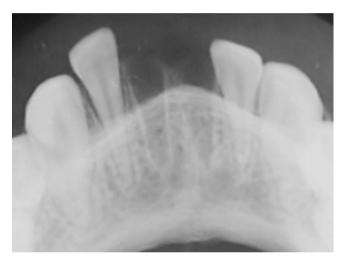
Lower occlusal radiograph shows a complete avulsion of the mandibular right and left central incisors
